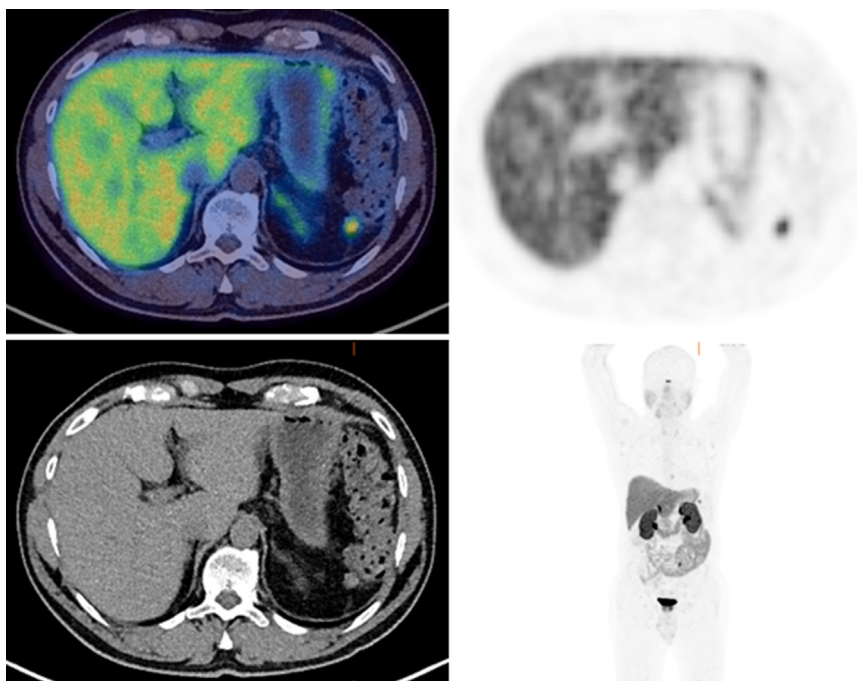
A 61-year-old man underwent follow-up ^{68}Ga -DOTATATE PET/CT imaging 6 months after a distal pancreatectomy and splenectomy for a well-differentiated NET found in the distal pancreas. There is focal uptake of tracer in a nodule in the left upper quadrant. This represents a small focus of accessory splenic tissue and not a metastasis. Learning point: Accessory splenic tissue is common after splenectomy; if any doubt, consider a colloid scan (which will not have uptake in NET but have uptake in splenic tissue).
